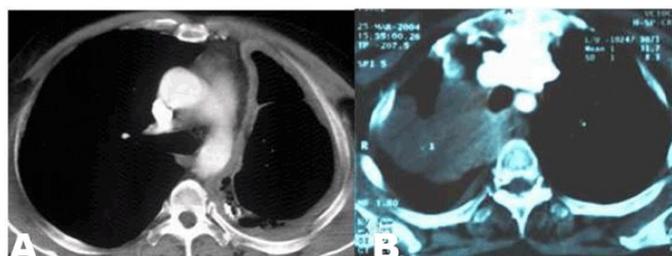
(A) CT scan showing a circumferential pleural thickening in a patient with malignant pleural mesothelioma, and (B) CT scan showing a pleural heterogeneous mass with extension to the adjacent organs in a patient with malignant form of solitary fibrous tumor.
